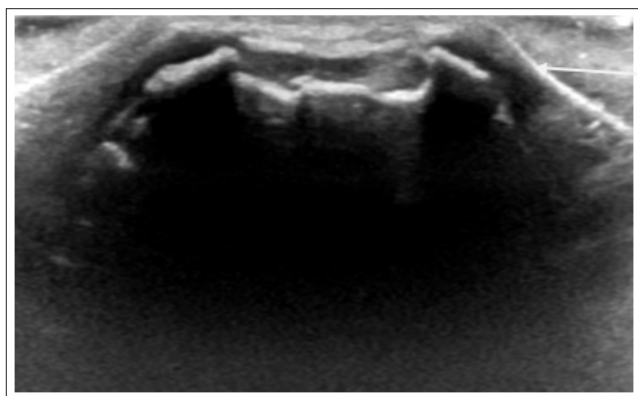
Ultrasound Examination of the Thoracic Mass Showing the Cartilaginous Cap (Arrow)
